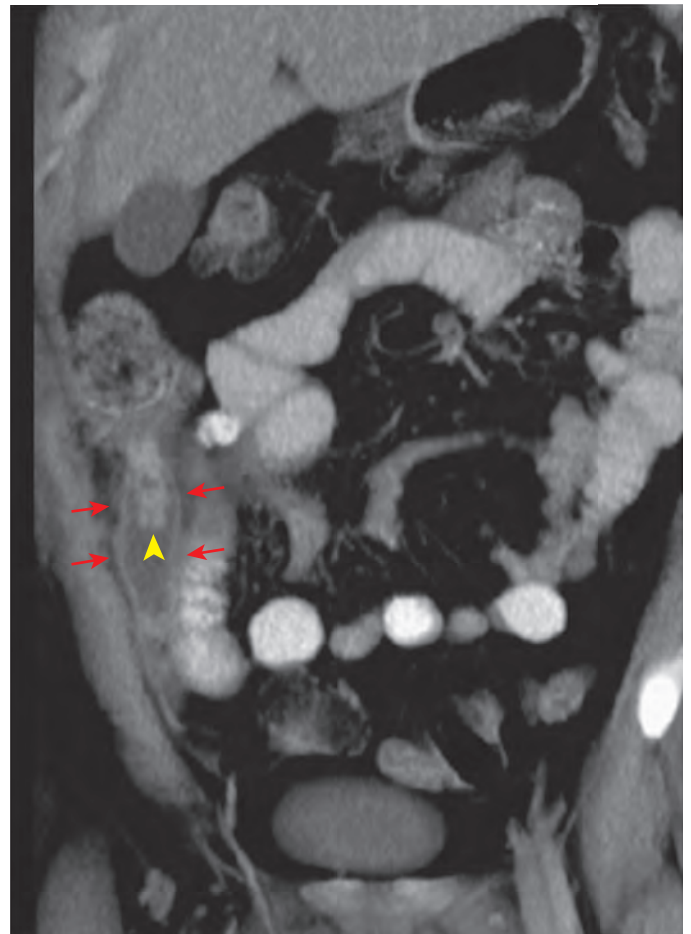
Acute appendicitis on enhanced CT. This coronal multiplanar reconstruction image shows the distended appendix (arrows) with multiple obstructing appendicoliths (arrowhead) at the appendiceal orifice. Note the mural wall thickening and enhancement, as well as the periappendiceal soft tissue stranding and fluid. On pathologic examination the appendix was shown to be perforated.
